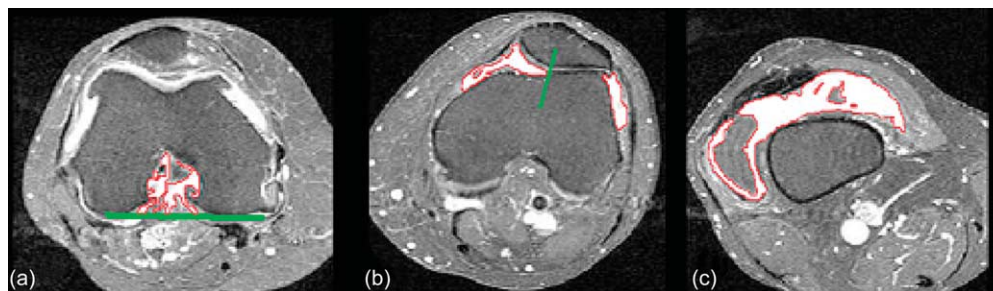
T1-weighted post-Gd-DTPA FS axial image with ROI (a) intercondylar notch, (b) medial and lateral parapatellar recess, and (c) suprapatellar pouch indicated.
